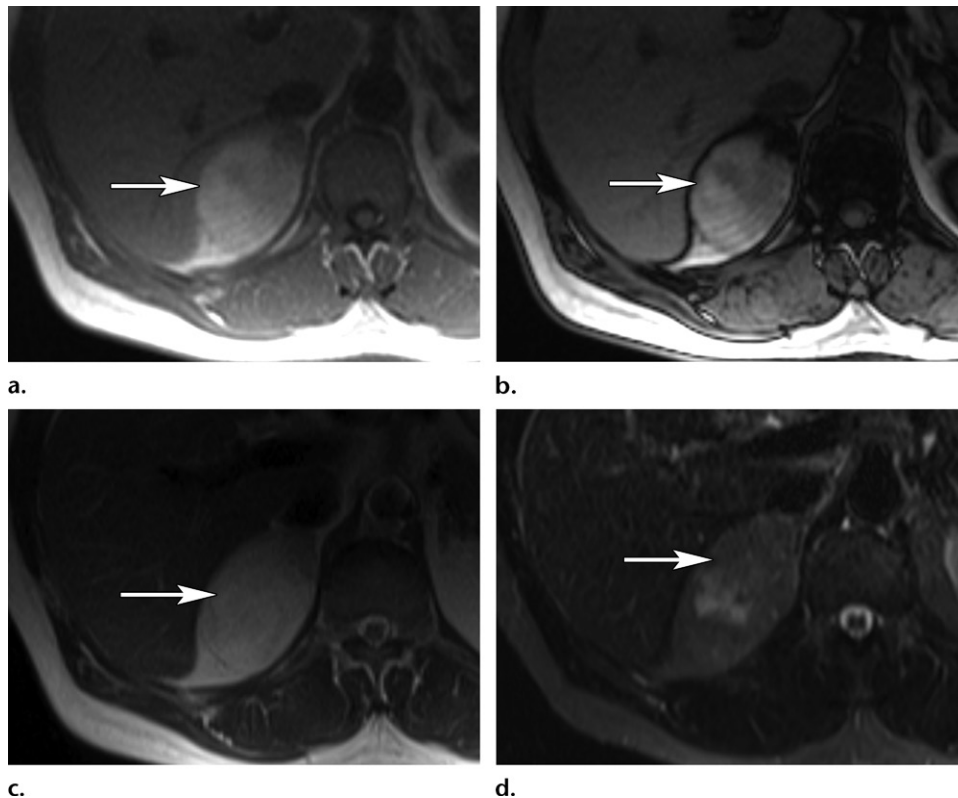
New suspicious liver lesions found at CT in a 58-year-old woman with metastatic melanoma. Axial T1-weighted in-phase (a) and opposed-phase (b) MR images show T1-hyperintense liver lesions (arrows), which become far more apparent (arrows on b) with background liver signal intensity loss from diffuse hepatic steatosis on the opposed-phase image, a finding consistent with metastatic melanoma.
